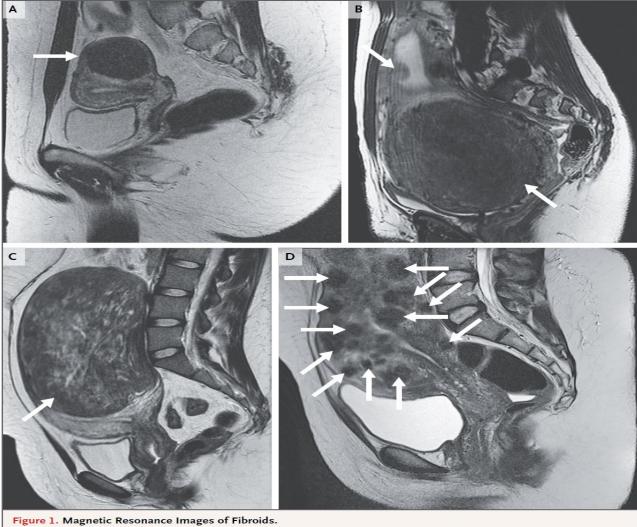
Magnetic Resonance images of Fibroi
